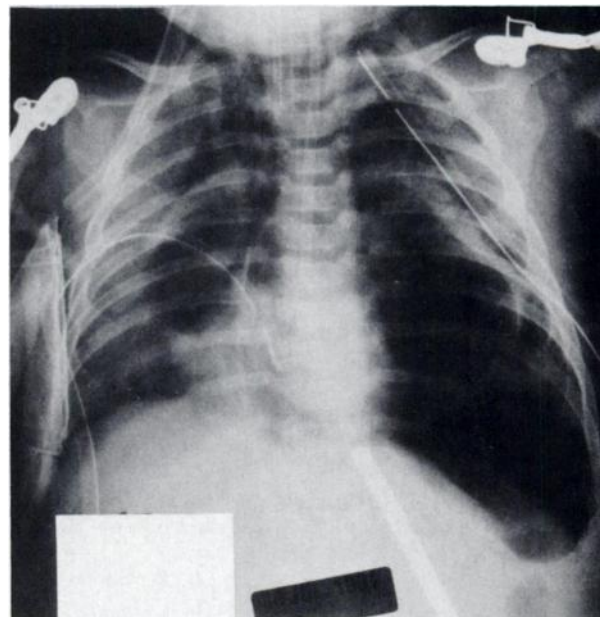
Chest x-ray film obtained shortly after initiating HFOV support.
